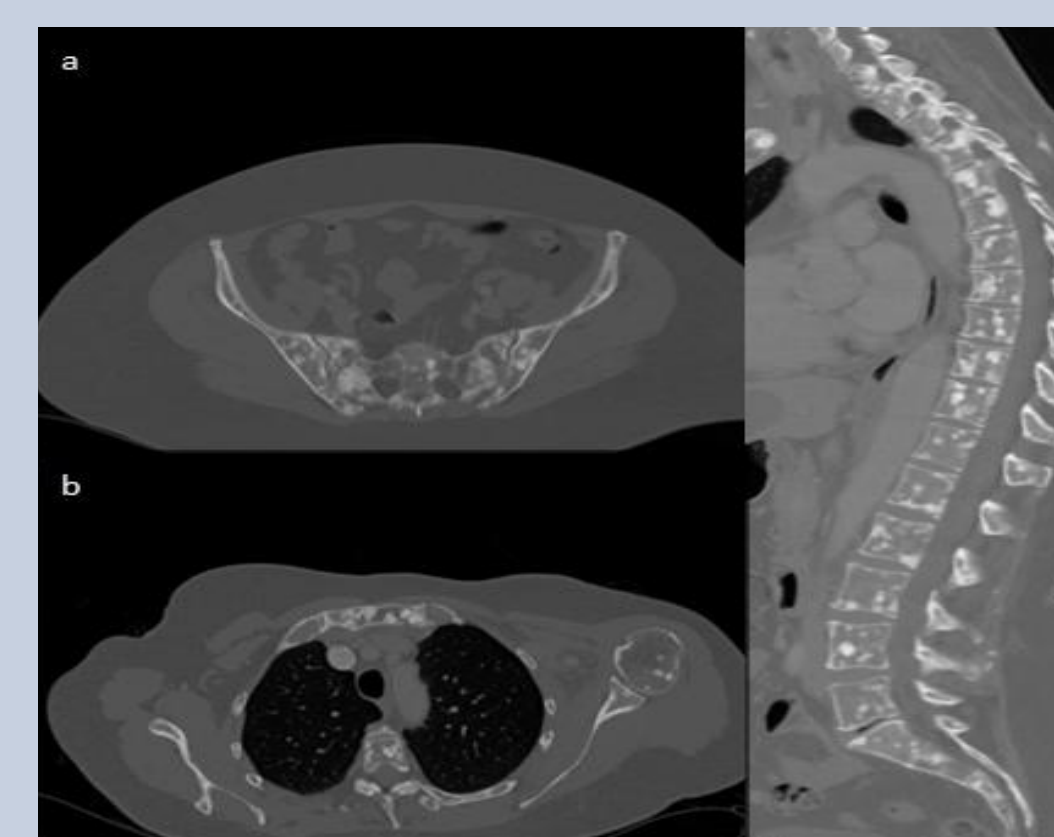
Axial CT of the pelvis and sagittal CT of the spine demonstrating multiple sclerotic bone lesions.
